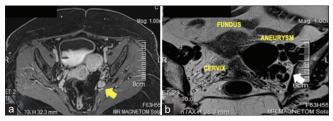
Magnetic resonance image/magnetic resonance angiogram images: (a) Dilated tortuous anterior branches of the left internal iliac artery and vein in the left side of the uterine cervix and lower uterine segment. (b) Saccular aneurysm component
